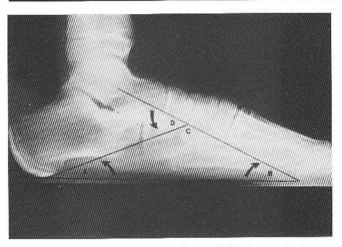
Pronated foot x-ray. A. Calcaneal inclination angle changes very little with pronation. B. Talar declination angle changes quite a bit, increasing with pronation. D. The lateral talocalcaneal angle also changes a great deal, increasing with pronation.
